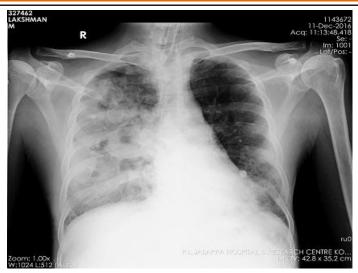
Chest x-ray showed non-homogenous opacities in right lung, upper, middle and lower zones and two thin walled cavities in right lung middle and lower zones.
